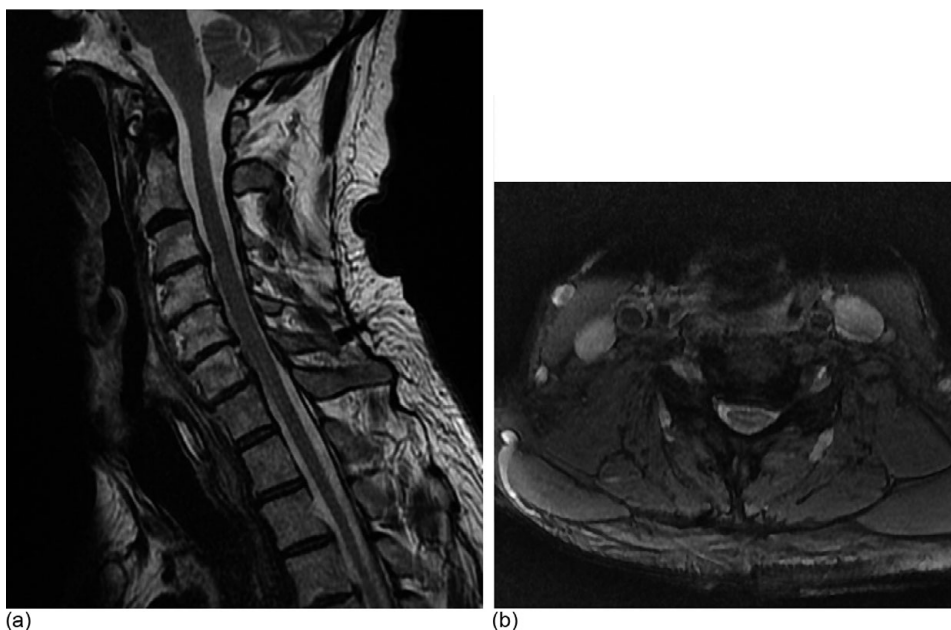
(a) Sagittal T2 and (b) axial T2 at C5/6 MRI images of cervical spine
